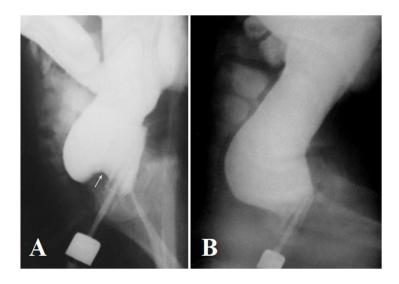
Lateral roentgenograms of anorectum in children in different stages of the FC. The true diameter of the marker located near the anus is 1.6 cm. A. Child of 3 years. There is a typical concavity (arrow) on the lower contour of the rectum due to hypertrophy and/or edema of the PRM. The length of the anal canal is 3.6 cm (the maximum normal limit is 2.8 cm. The width of the rectum is 4 cm (the maximum normal limit is 3.7 cm. B) In a patient of 8 years, the width of the rectum is 5.6 cm (the maximum limit of the norm - 4.1 cm). The length of the anal canal is 2.1 cm (the minimum limit of the norm - 2.6 cm). The upper part of the anal canal, including the PRM and IAS, are in constantly stretched state, i.e. are not involved in the feces retention.
